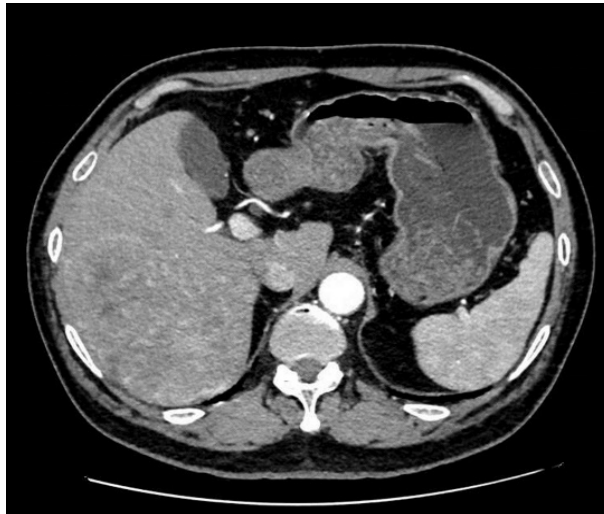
First admission to CT: The tumor was significantly enhanced in the right hepatic lobe artery stage.
